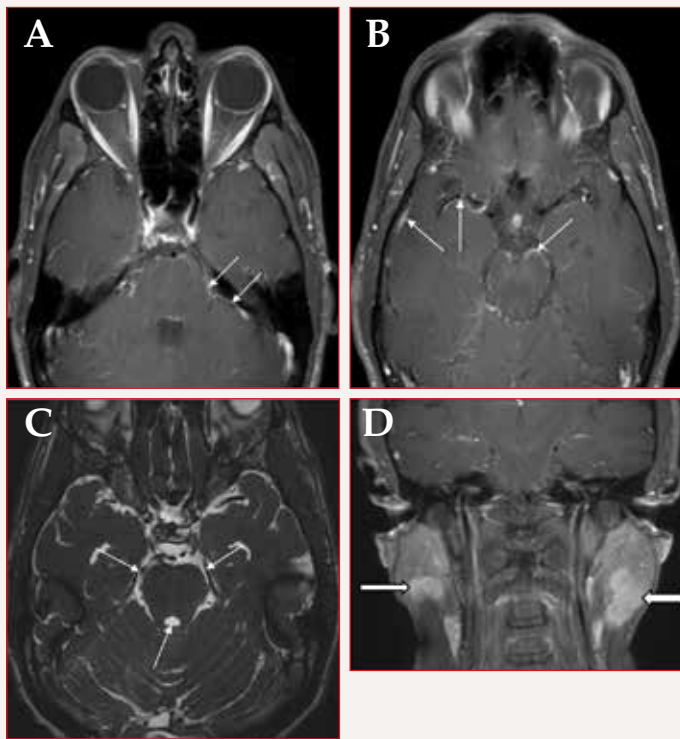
Magnetic resonance imaging scans showing (A-C, arrows) pachymeningeal and leptomeningeal enhancement in the posterior fossa, brainstem, and vermis of the cerebellum. (D) Bulky lymphadenopathy of parotid glands (arrows).
